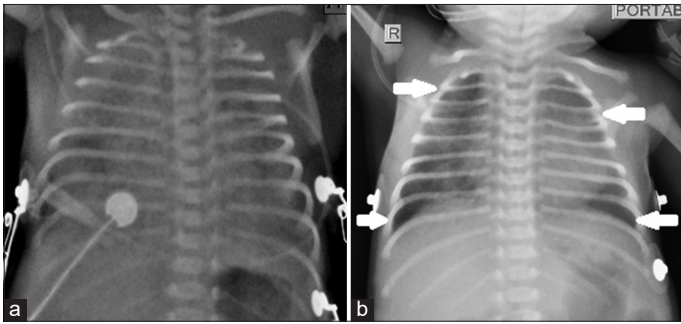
Chest X-ray AP view showing (a) bilateral infiltrates completely filling the lung fields; (b) clearing of infiltrates (shown by white arrows) from apical and basal regions of lung fields which were previously filled with infiltrates with persistence of fluffy infiltrates in remaining areas
